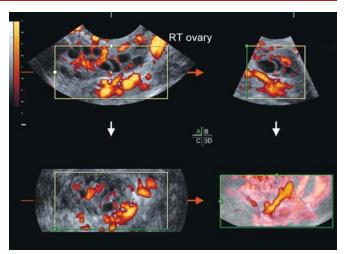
3D power Doppler volume of ovary
